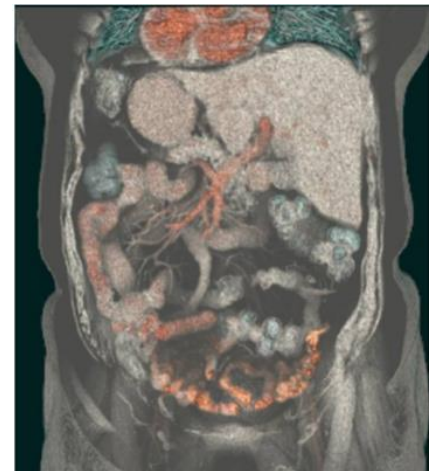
abdominopelvic CT with enhancement of abdominal viscera.
